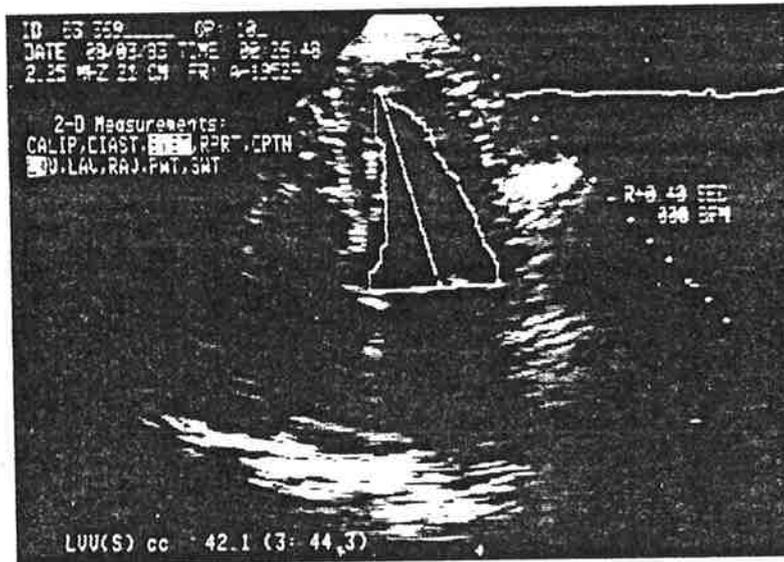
APICAL TWO CHAMBER VIEW (STOP FRAME IMAGE)
